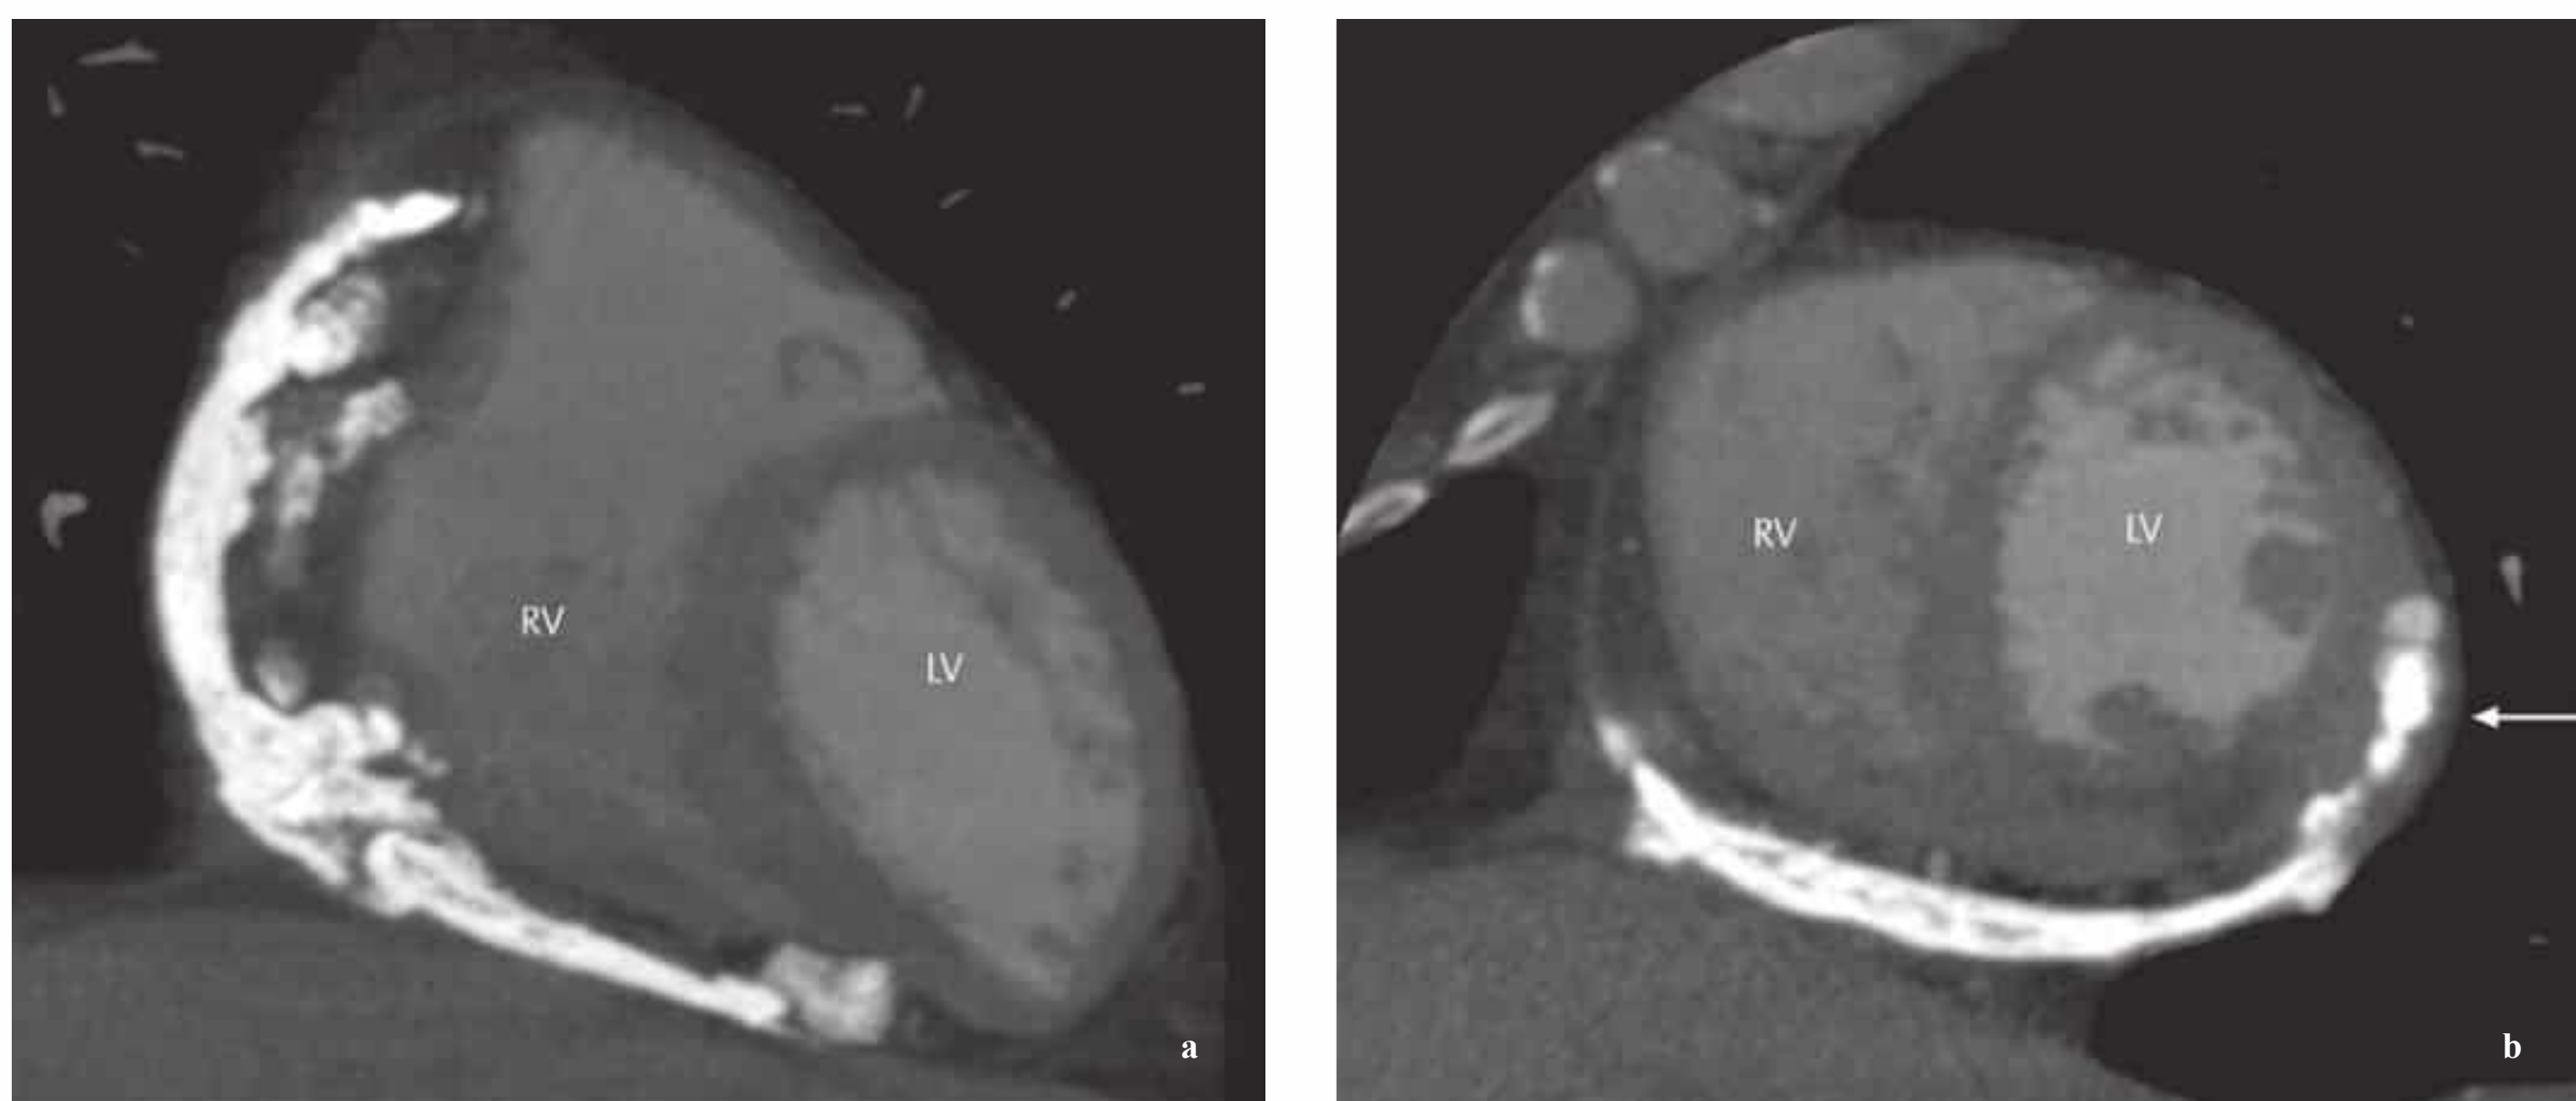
a, b Patient with posttraumatic constrictive pericarditis years after sustaining a knife wound. CT was done in preparation for a pericardial resection and coronary artery revascularization. Note the extensive, flocculent pericardial
